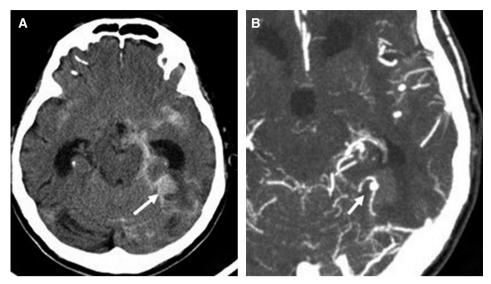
(A) CT on admission shows diffuse subarachnoid hemorrhage and intracranial hemorrhage (arrow). (B) CT angiography shows the distal left PCA aneurysm (arrow). PCA: posterior cerebral artery
